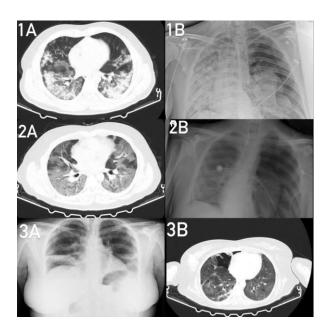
Chest X-ray and CT scan of surviving cases; 1A, 2A, and 3A imaging at admission. 1B, 2B, and 3B imaging on occurrence of SP.
